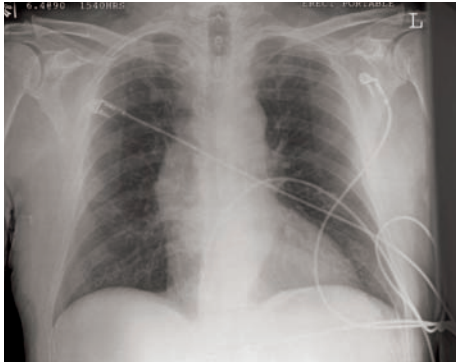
Chest X-ray showing a widened mediastinum.
